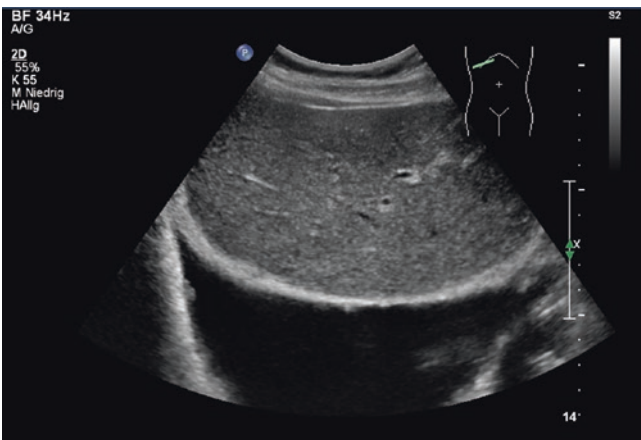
Patient with breast carcinoma supposed to have a singular liver metastasis. Sonographically a pleural effusion with small metastasis in the pleural recesses
